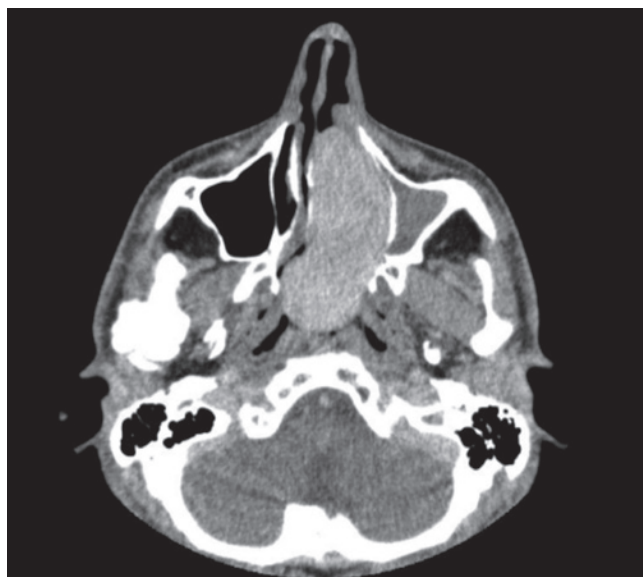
Sinonasal and rhinopharyngeal solitary fibrous tumour. CT image axial section.
